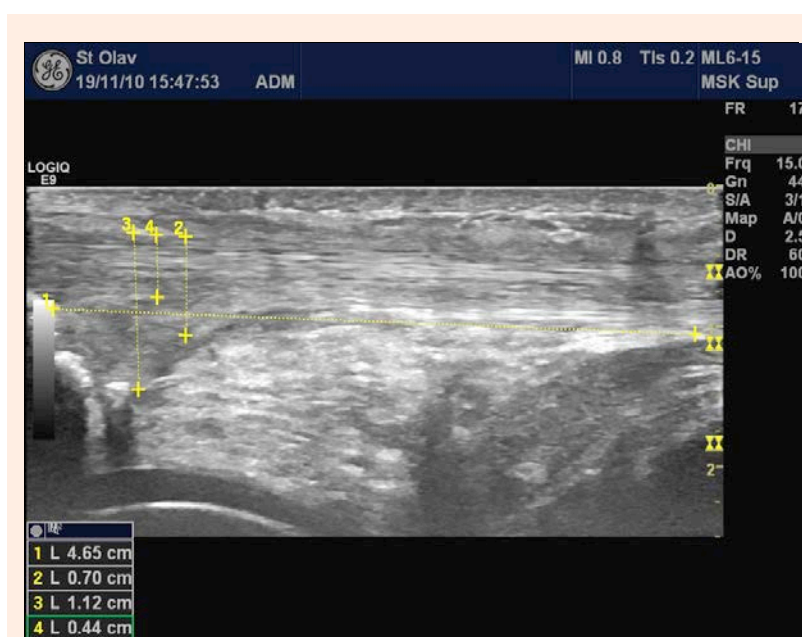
Measurements of (proximal) thickness and length, patellar tendon, greyscale ultrasound – longitudinal scan. (Photo by Salvesen ES)
